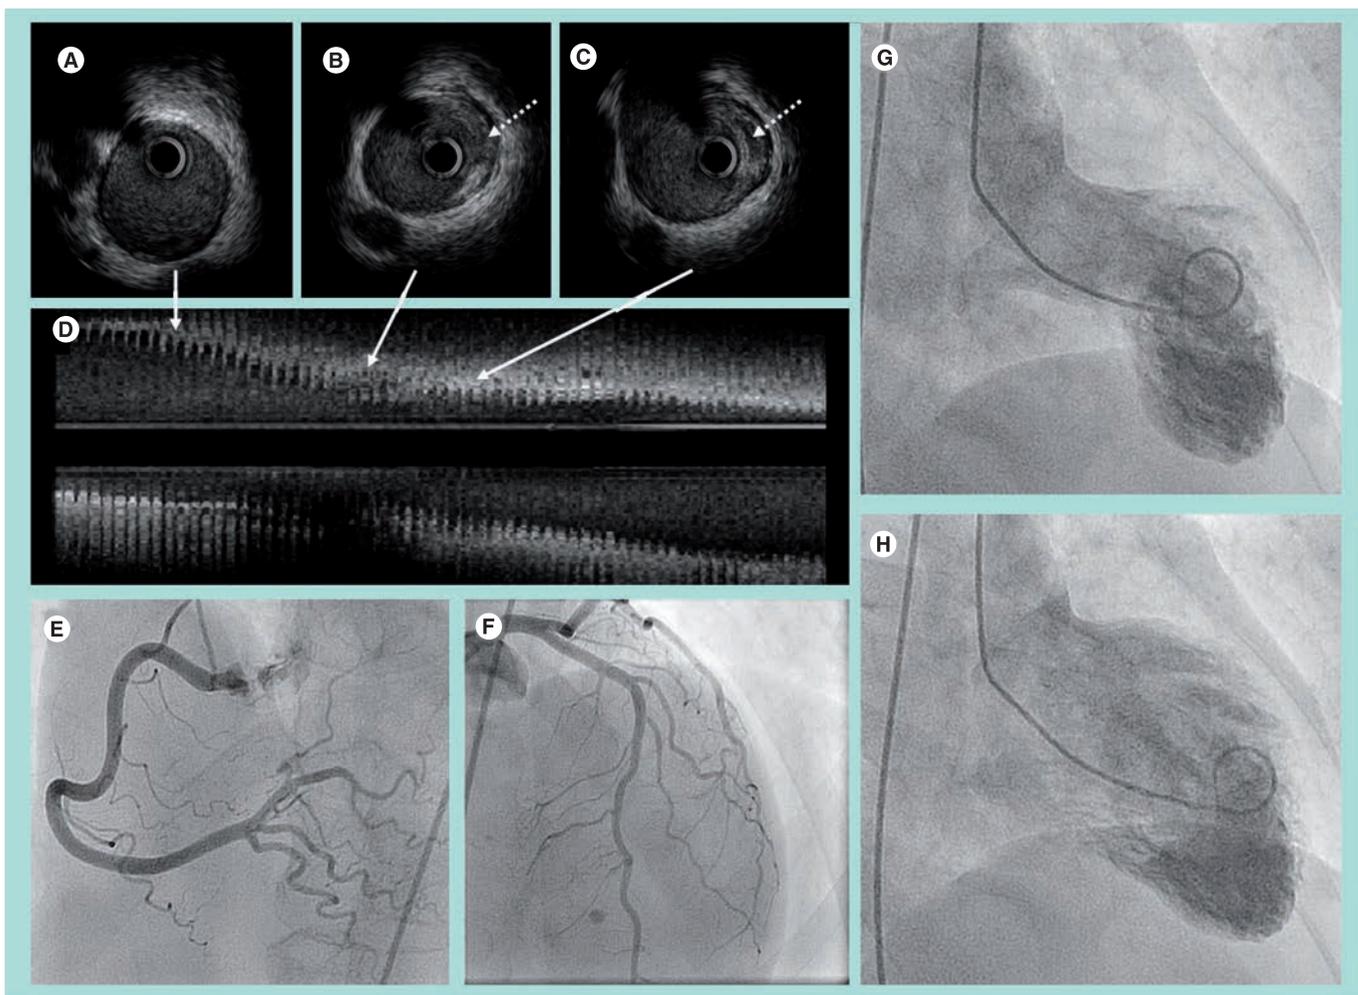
A 60-year-old woman presenting with severe chest pain after an emotional distress. (A–D) Intravascular ultrasound imaging showed the presence of a proximal ruptured plaque (dashed arrows) in the proximal left anterior descending artery. (E & F) Angiography showed normal coronaries. (G & H) Ventricle angiogram showed the typical abnormal contraction pattern described in 'Takotsubo cardiomyopathy'.
